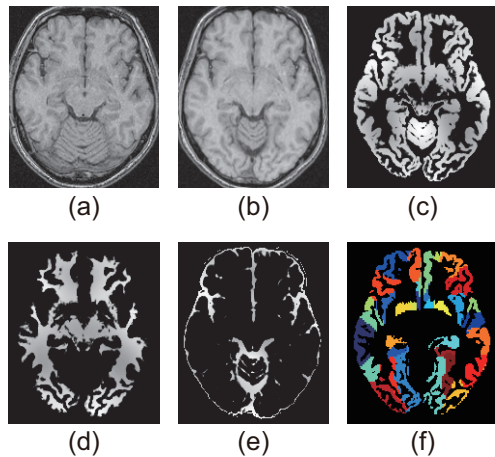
Results of preprocessing: (a) T1-weighted image, (b) normalized T1-weighted image, (c) normalized, modulated GM, (d) normalized, modulated WM, (e) normalized, modulated CSF and (f) parcellated local regions of GM, where each color label indicates a segment.
